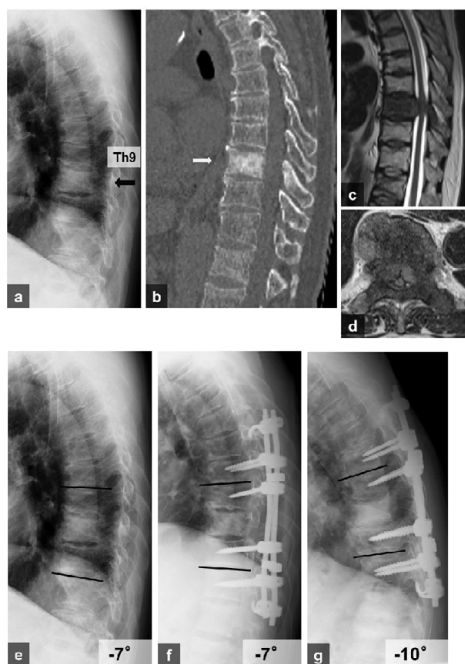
A 64-year-old man who suffered metastasis of prostate cancer at Th9. (a. pre-operative lateral radiograph, b. pre-operative computed tomography, c. d. pre-operative T2-weighted magnetic resonance images). Lateral radiographs show correction and loss of correction of local kyphosis (angle between lines) at pre-operation (e), post-operation (f), and follow-up (g).
